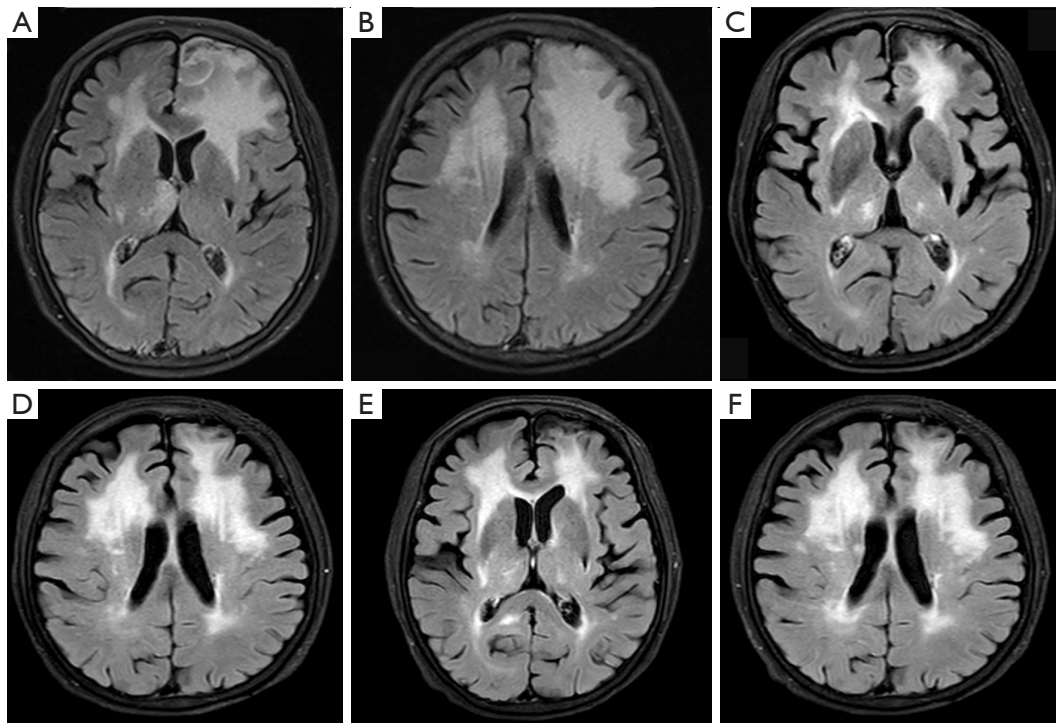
MRI of the brain for the patient. (A,B) MRI with relapse in September 2022. (C,D) MRI after toripalimab and rituximab treatment in January 2023. (E,F) MRI of progressive disease in June 2023. MRI, magnetic resonance imaging.
